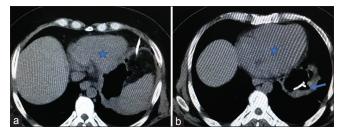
(a) Left subphrenic abscess collection following sleeve gastrectomy for morbid obesity very close to the heart (star). (b) Treated with computed tomography-guided percutaneous drainage insertion (arrow)
